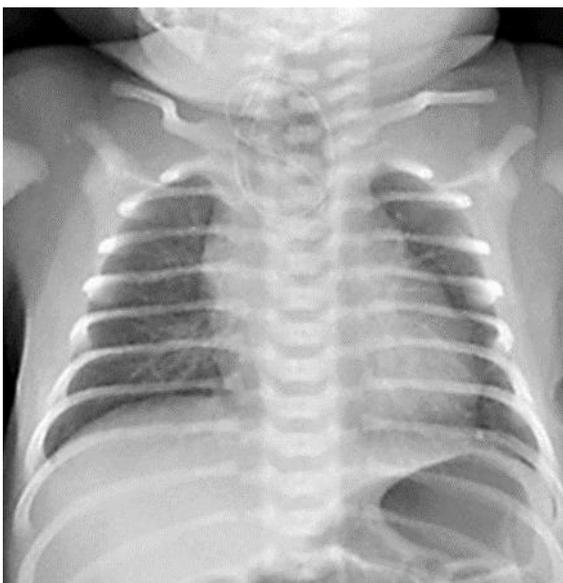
Chest radiograph showing opacity in the right upper zone and coiling of the orogastric tube
